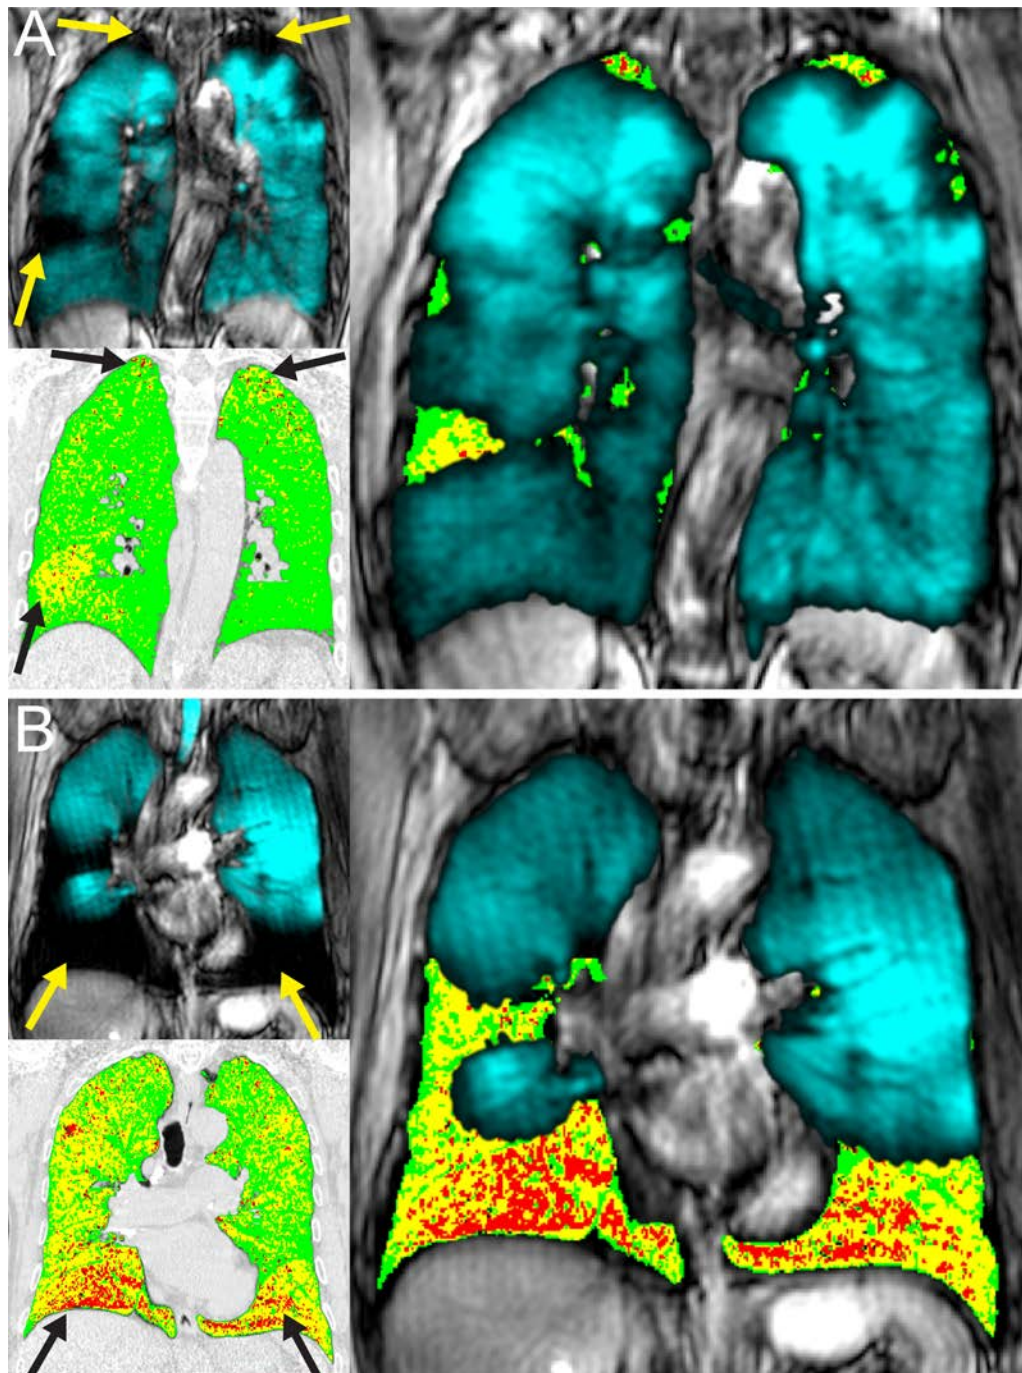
Spatial relationship of ^3He MRI ventilation defects with PRM gas-trapping and emphysema for a representative (A) mild and (B) severe COPD subject
